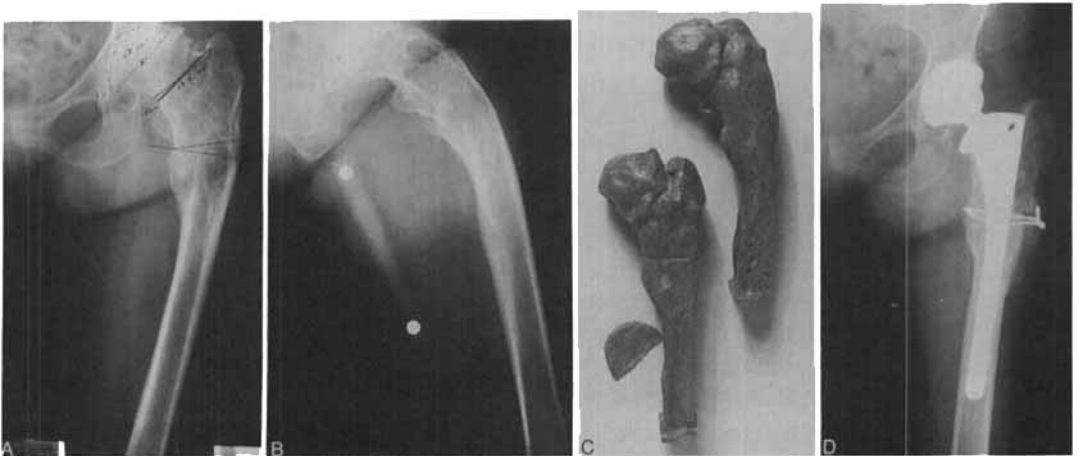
7D. (A) AP radiograph of the left hip in a 61-year-old woman with malunited intersubtrochanteric fracture and secondary degenerative joint disease. (B) Lateral preoperative radiograph of the left hip. (C) CT-scan-generated foam models to assist in preoperative planning. (D) Postoperative radiograph shows completion of the two-plane derotational osteotomy to correct varus, posterior angulation, and retroversion. A collared cementless prosthesis with onlay autograft was used for fixation of the osteotomy, which healed within eight weeks.
